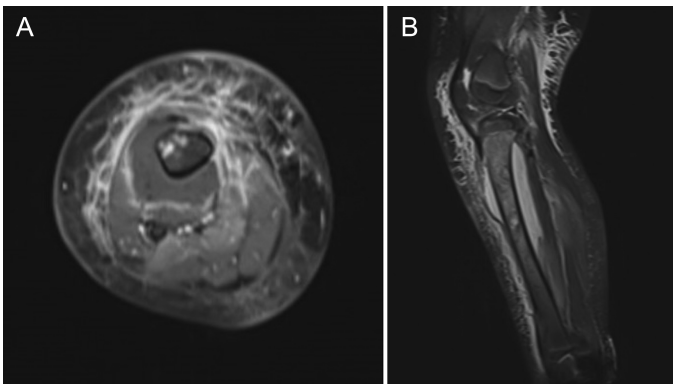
(A, B) Gadolinium contrast-enhanced fat-suppressed axial T1-weighted and coronal T2a-weighted crural magnetic resonance images. Subperiosteal abscess with peripheral contrast enhancement and bone marrow edema at the proximal half of the tibia indicate osteomyelitis.
